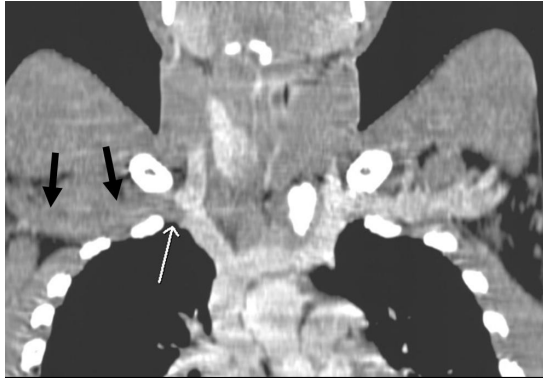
Thoracic CT MPR image shows thrombotic occlusion of right subclavian vein (arrow).
